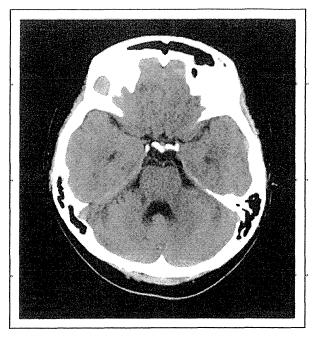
Coronal computed tomography at onset of symptoms in patient showing a lesion in the right middle cerebellar peduncle.
